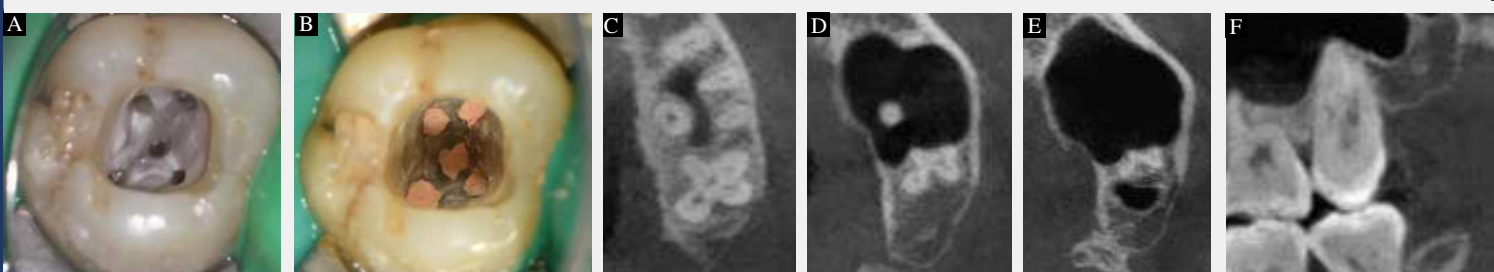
(A) The clinical photo after access opening. (B) The clinical photo after canal filling. (C,D,E) 5 canals, including two palatal canals, as seen in the CBCT coronal view. (F) Two palatal canals as seen in the CBCT sagittal view.
